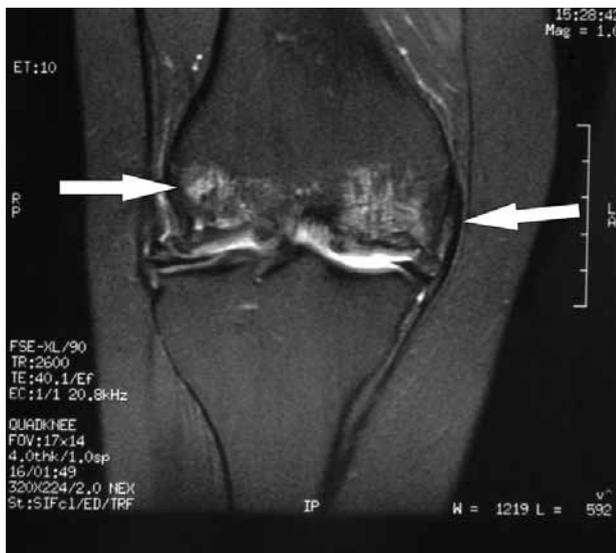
Right knee, MRI  $T_2$
